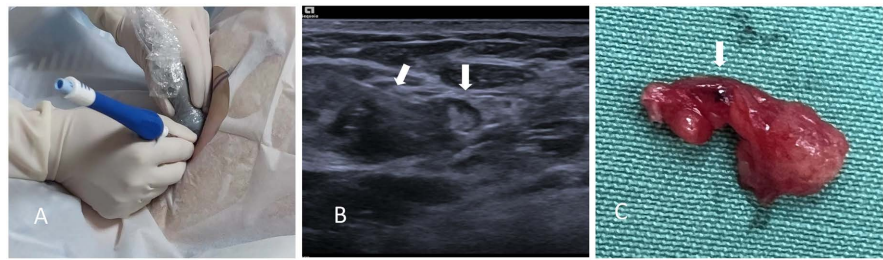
(A) Ultrasound-guided puncture, placed marker in the sentinel lymph node with suspected metastasis. (B) Needles and sentinel lymph nodes seen on ultrasound (arrow); (C) Surgical removal of sentinel lymph node with internal marker (arrow).
